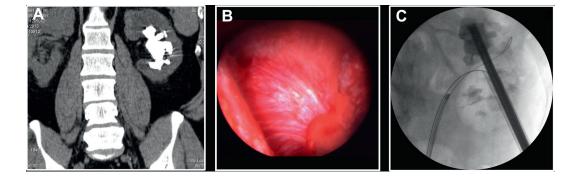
Typical successful rigid nephroscope access to upper calyx through lower calyx tract with patient supine. *A*, preoperative coronal CT shows 55 mm complete staghorn stone in left kidney. Note characteristic position of kidney with upper pole median and lower pole lateral. *B*, Intraoperative endoscopic view reveals upper calyx papilla in center of endoscopic field. *C*, intraoperative pyelography demonstrates position of nephroscope tip in upper calyx.
